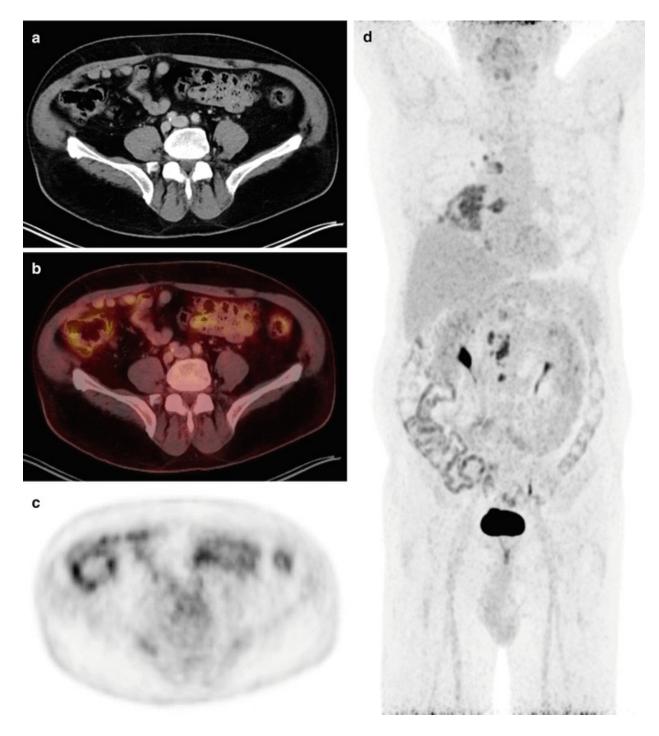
63 year old male patient suffering diabetes type 2 who underwent hybrid imaging for wholebody lung cancer staging. Morphological CT (\mathbf{a}), fused PET/CT (\mathbf{b}) and PET images (\mathbf{c}) as well as a PET maximum intensity projection image (\mathbf{d}) are displayed. Due to treatment with metformin, an intense tracer uptake can be observed in the colonic wall
